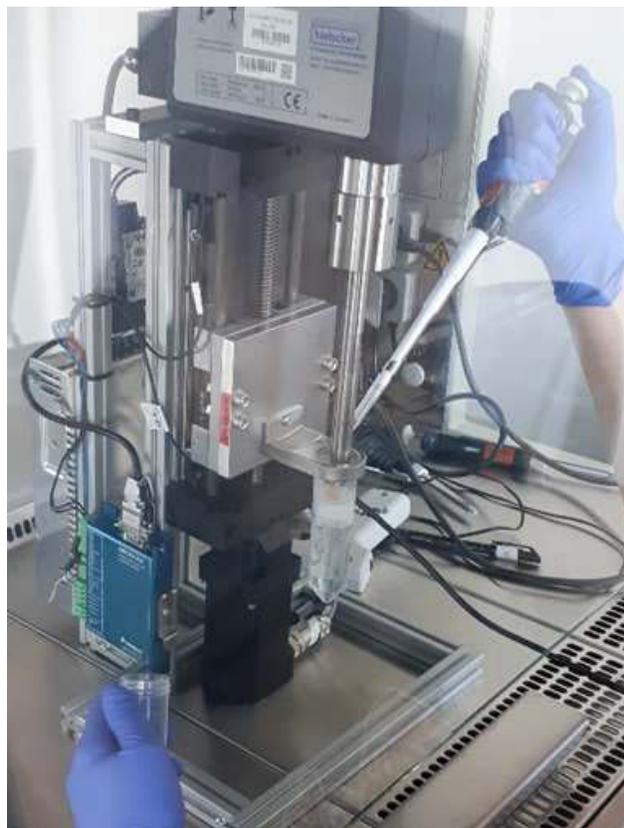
Principle of ultrasonic decellularization
